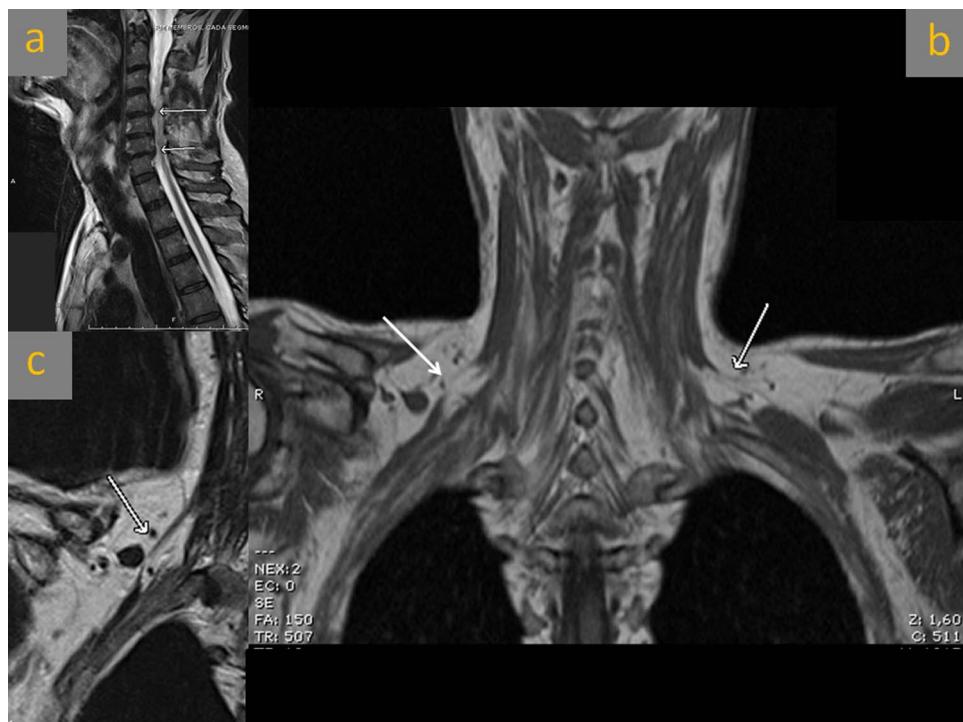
(A) Cervical MRI showing moderate degenerative changes, moulding of the subarachnoid space at C5–C6 and C6–C7 (arrows), without any sign of spinal cord lesion; (B) Short tau inversion recovery imaging showing bilateral hyperintense, enlarged trunks (arrows) compatible with postganglionic brachial plexus lesion (axonotmesis or neurotmesis); (C) Amplified image of plexus injury (right side).
